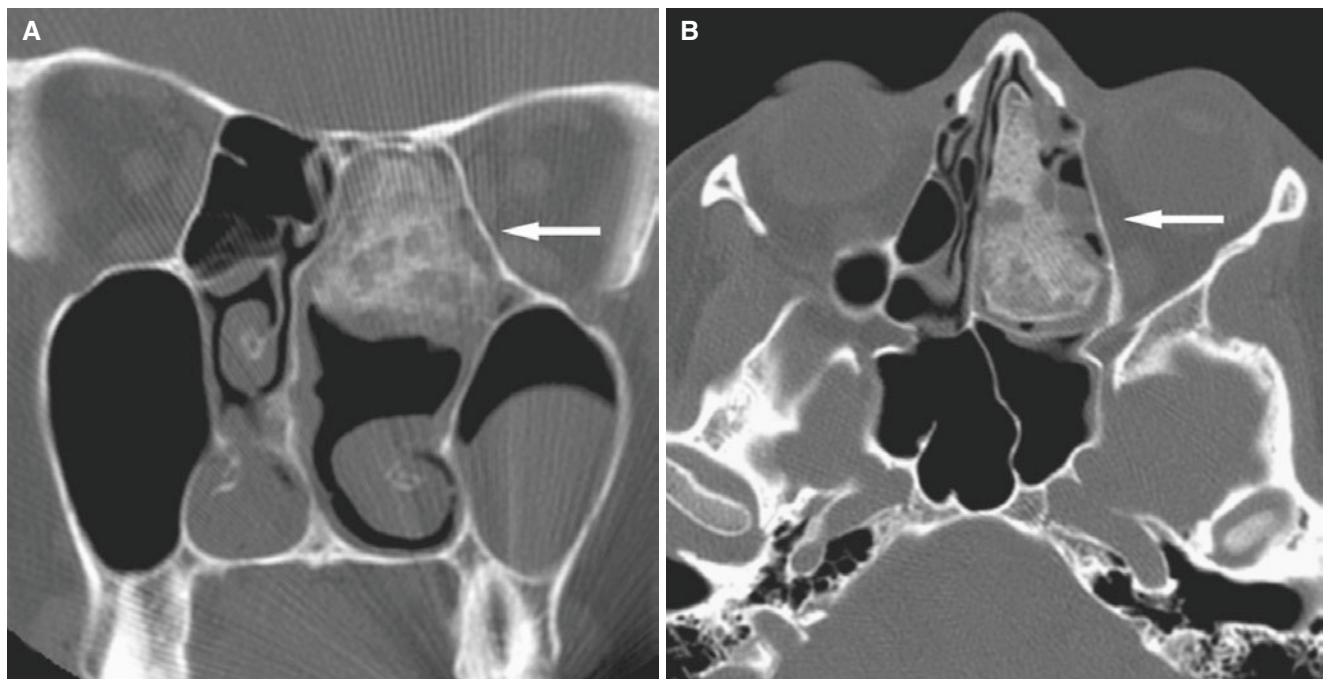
Ethmoid adenocarcinoma (low grade); 18-year-old female, complaining of headache, following biopsy of ethmoid sinus mass. (A) Coronal CT image shows rather well-defined, dense mass in the left ethmoid sinus (*arrow*) with some displacement of the nasal septum to the right and expanding into the nasal cavity. Left middle turbinate not
